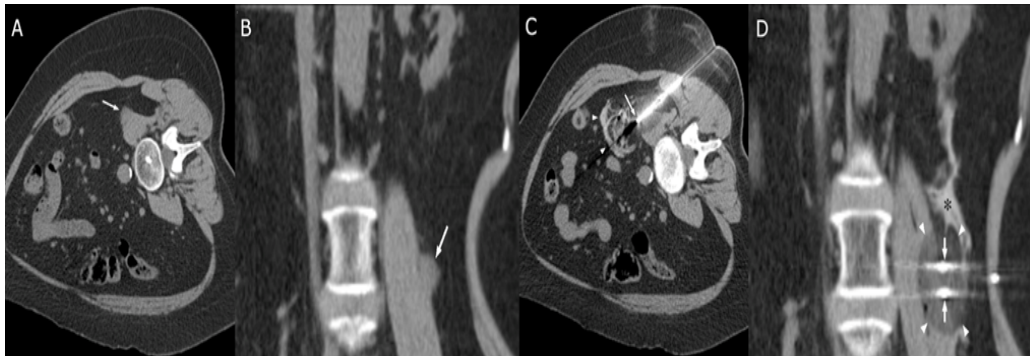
CT-guided Cryoablation Procedure: A. Axial pre-procedure CT image demonstrates interval increase in size of the left retroperitoneal soft tissue mass abutting the psoas muscle (white arrow). B. Coronal pre-procedure CT image demonstrates interval increase in size of the left retroperitoneal mass abutting the psoas muscle (white arrow). C. Intraprocedure axial CT image demonstrates the cryoprobes with surrounding ice ball encompassing the mass (white arrow). Hydro protection fluid (arrowheads) is present between the ablation zone and bowel/ureter. D. Intraprocedure coronal CT image demonstrates two cryoprobes (white arrows), less than 2 cm apart, bracketing the soft tissue mass with surrounding ice ball (white arrow heads) encompassing the nodule. Hydro protection fluid (black asterisk) is present between the ablation zone and bowel/ureter.
